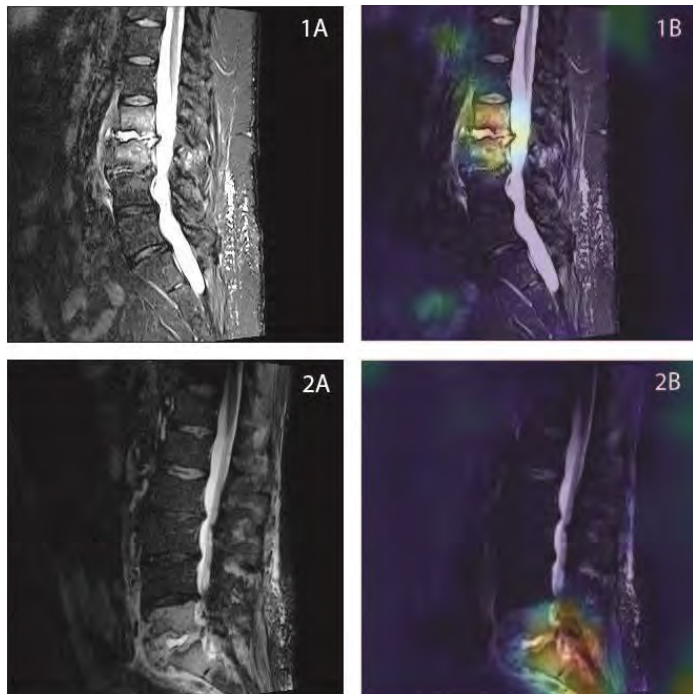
Left column demonstrates the original lumbar spine MRI STIR images and the right column demonstrating gradCAM overlay indicating identified discitis osteomyelitis.
